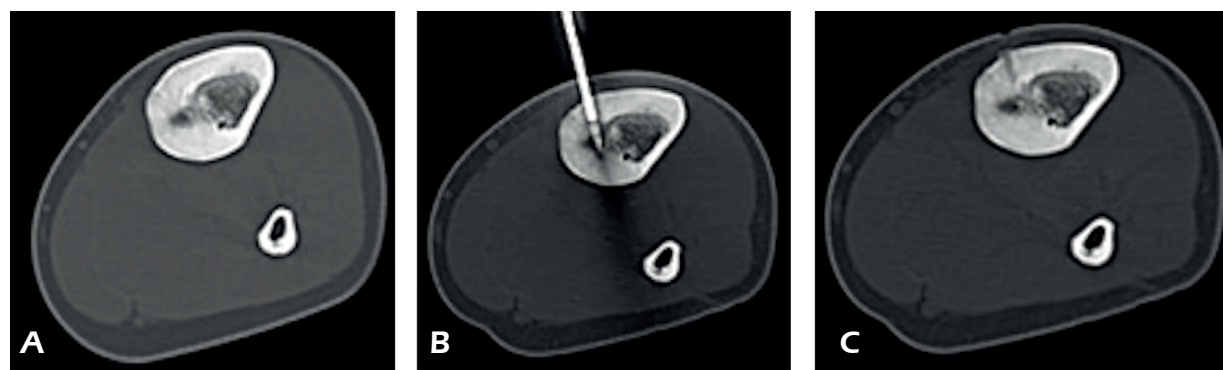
RFA for a 16 mm diameter osteoid osteoma of the left tibia. A, An axial computed tomography (CT) images shows an ovoid lesion with central calcification and surrounding sclerosis. B, CT scan shows the position of the electrode (arrow) within the nidus. C, Control CT scan at the end of the procedure.
